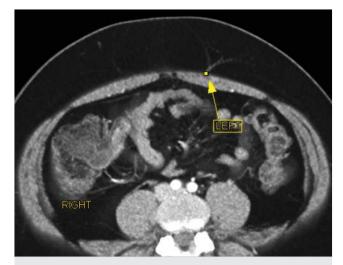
Computed tomography angiography of the abdomen demonstrating a large perforating vessel originating from a medial branch of the deep inferior epigastric artery. The exact position can be determined using this technique.
